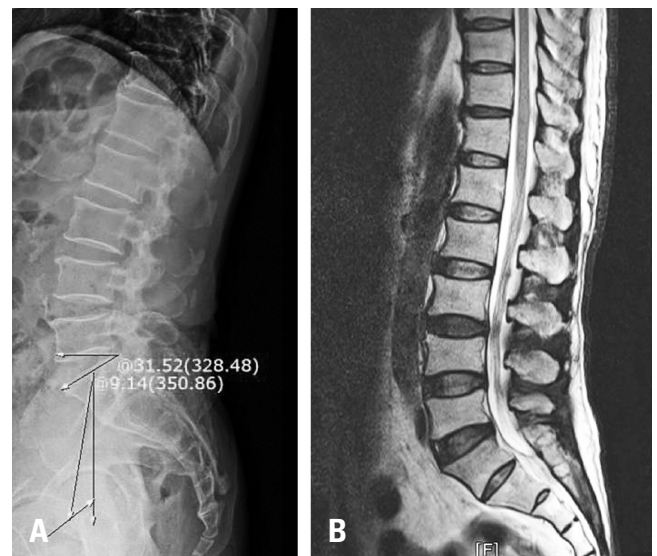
Radiography of a 69-year-old male with low pelvic tilt. (A) Upright lateral X-ray. (B) T2 sagittal image of lumbar magnetic resonance imaging.
